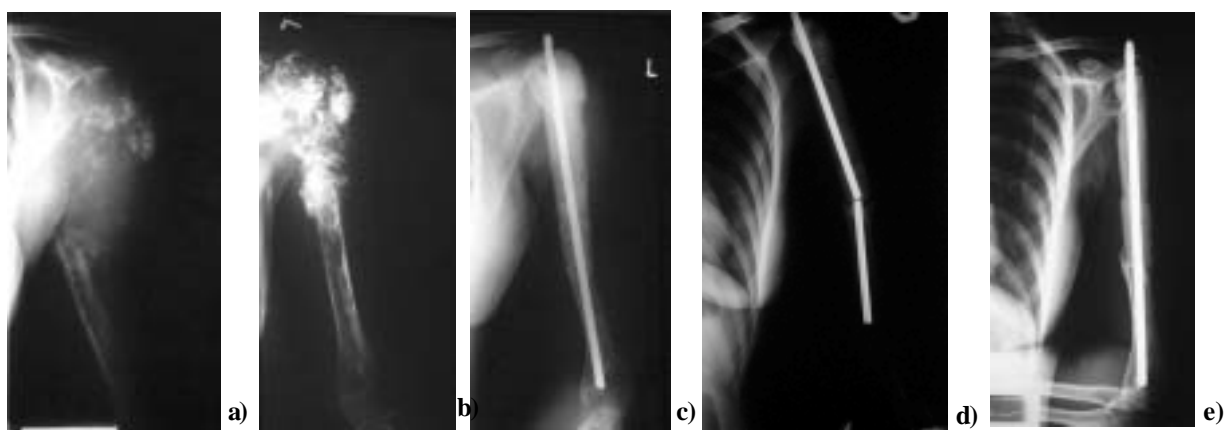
a) Fourteen-year-old female osteosarcoma patient with pathological fracture of the left proximal humerus at the first presentation. The patient had preoperative (neo-adjuvant) chemotherapy with Swedish Sarcoma Protocol XIV. b) Excellent response (>90% tumor necrosis) with sclerosation after neo-adjuvant chemotherapy (arrow shows the site of pseudo-healing of the pathological fracture). c) Radiograph of the humerus after wide resection of the osteosarcoma, and first stage reconstruction of the bone with intramedullary rod and bone cement. d) “Stress-fracture” of the intramedullary rod 6 years after the treatment. e) Considering the financial possibilities, reconstruction with new intramedullary rod was sufficient for the patient’s function.
